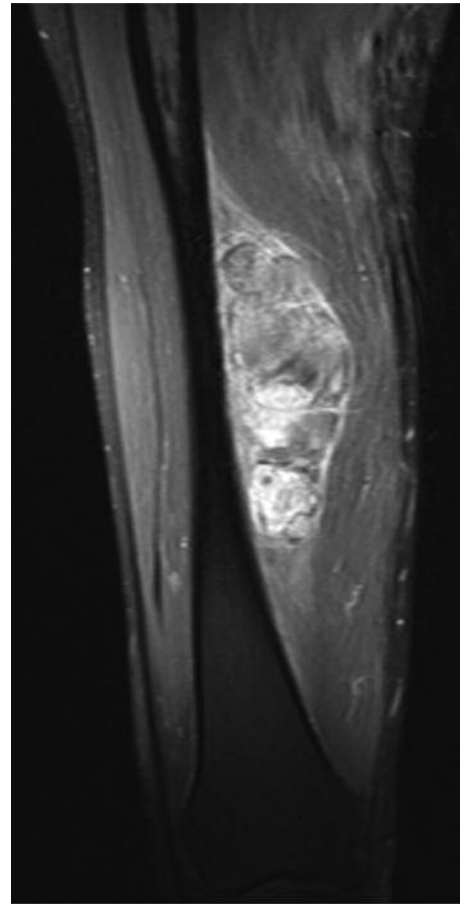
T2-weighted MRI showing heterogeneous enhancement of a large mass in the adductor compartment of the right thigh after intravenous contrast injection.
